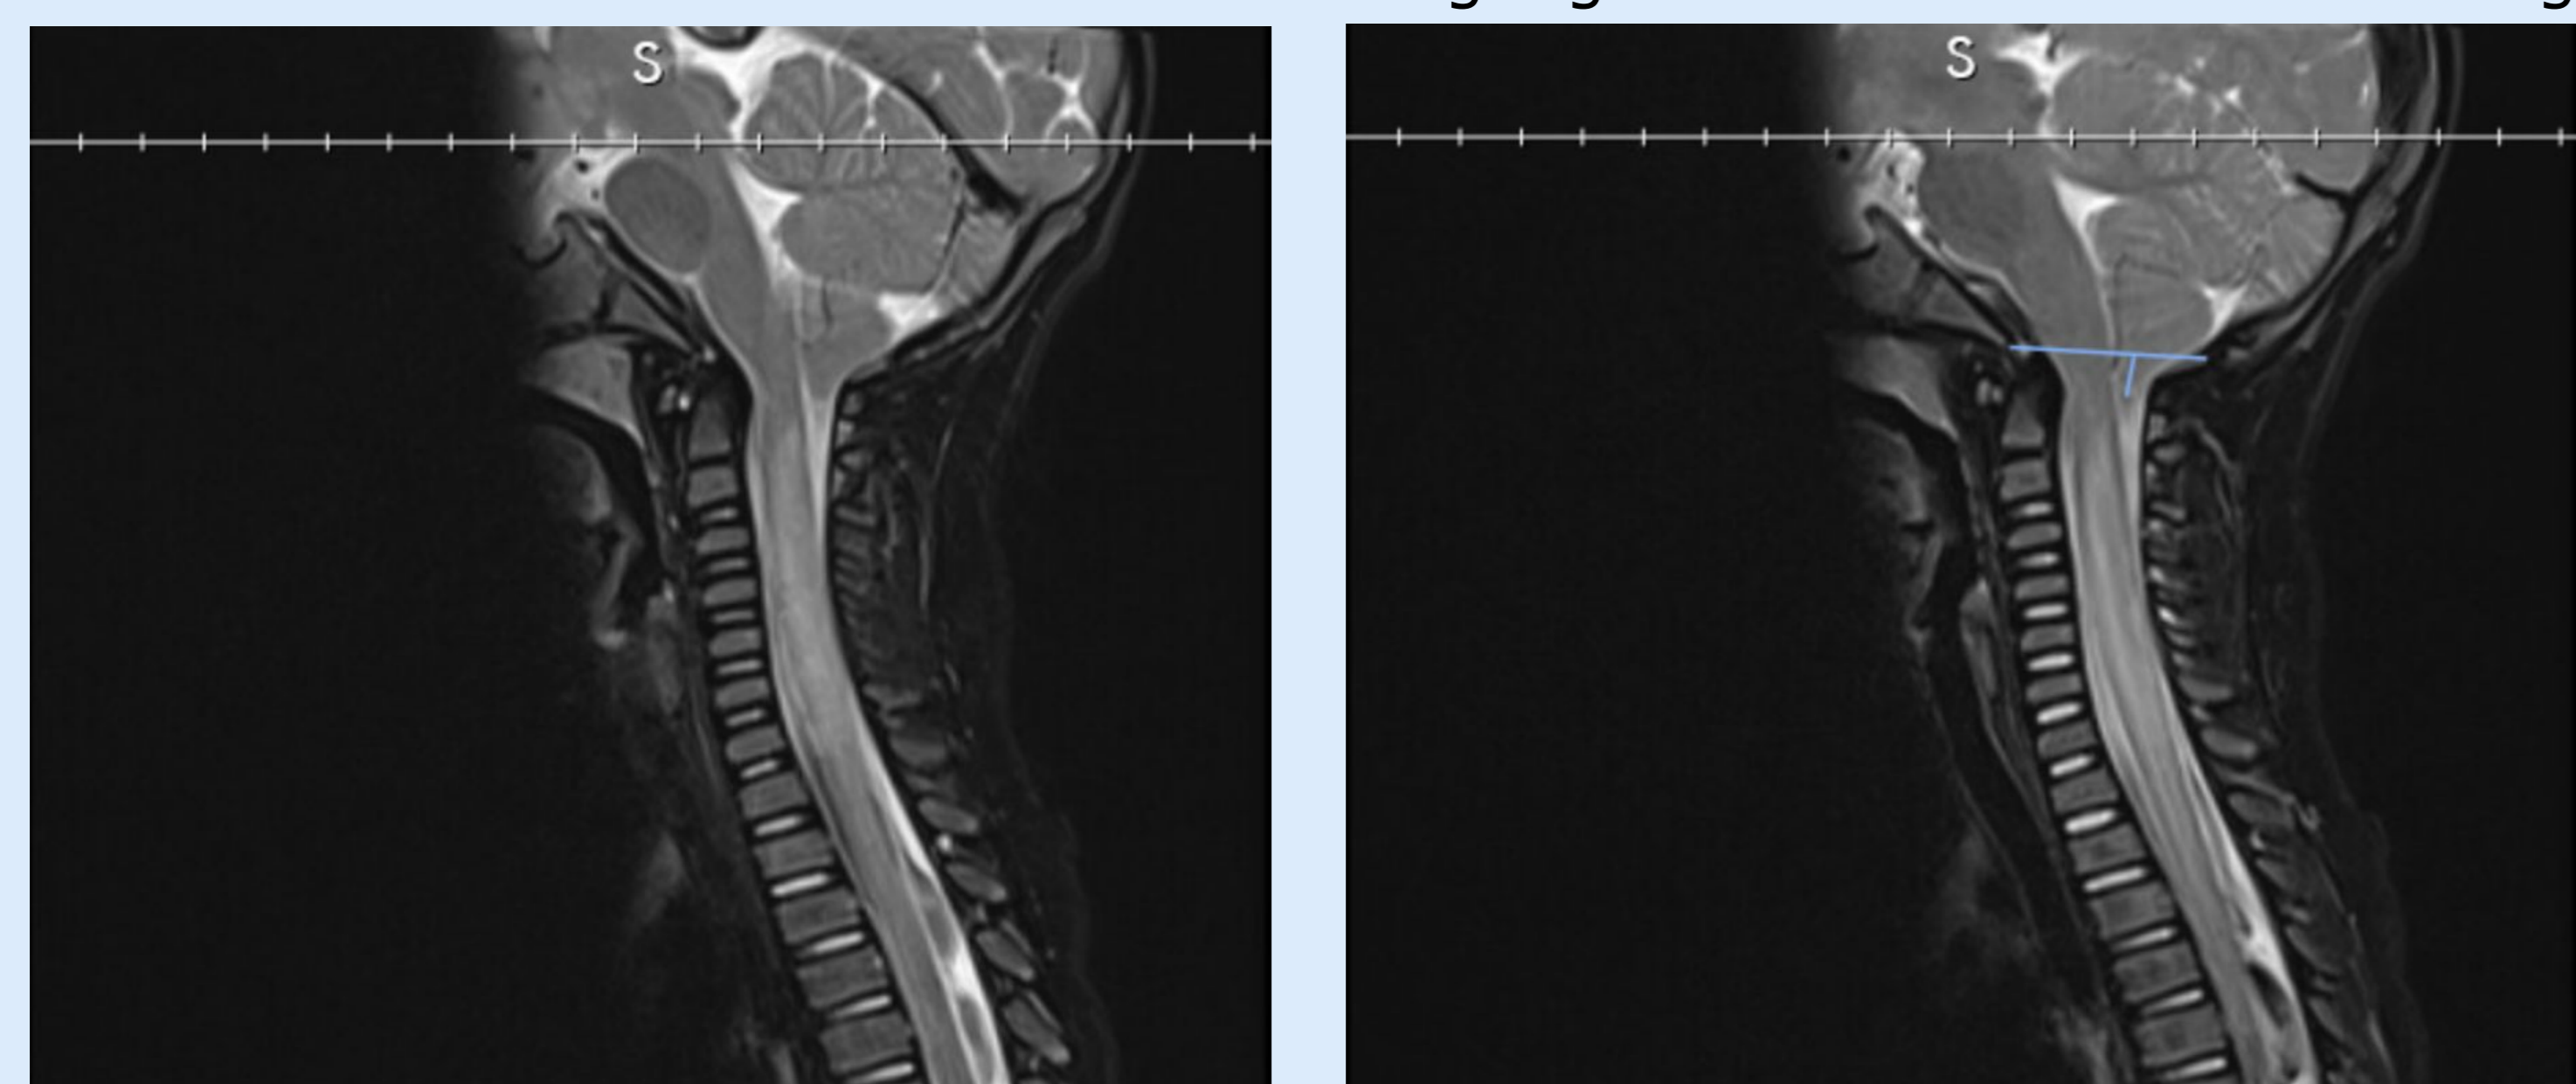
T2 weighted MRI of cervical spinal cord showing swelling with cord signal changes and diffusion restriction from levels C2-T3 with a ligamentous injury at C3 and Chiari I malformation.
